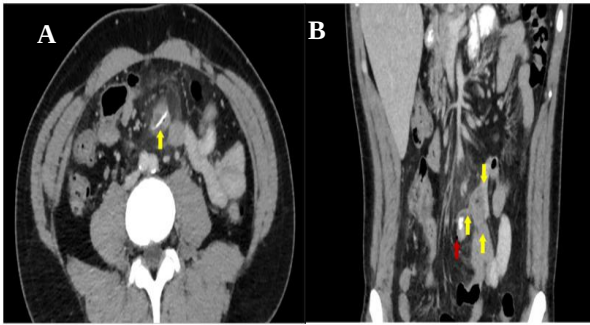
A) CT abdomen/pelvis axial view showing a foreign body (yellow arrow) within the small bowel. There is surrounding fat stranding with no evidence of perforation, on this slice it is difficult to appreciate that this is a Meckel's diverticulum, B) a coronal section showing a Meckel's diverticulum given the lumen communicating between adjacent loops of bowel (yellow arrow). At the edge/within of the bowel wall, locules of air can be seen suggesting a potential perforation (red arrow).
